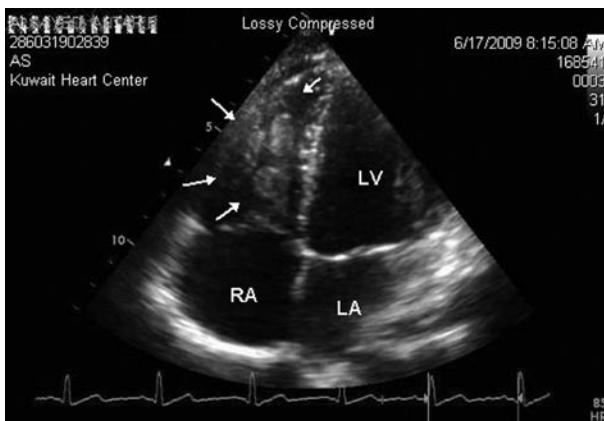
Transthoracic echocardiography showing right ventricular masses (4 chambers views)
